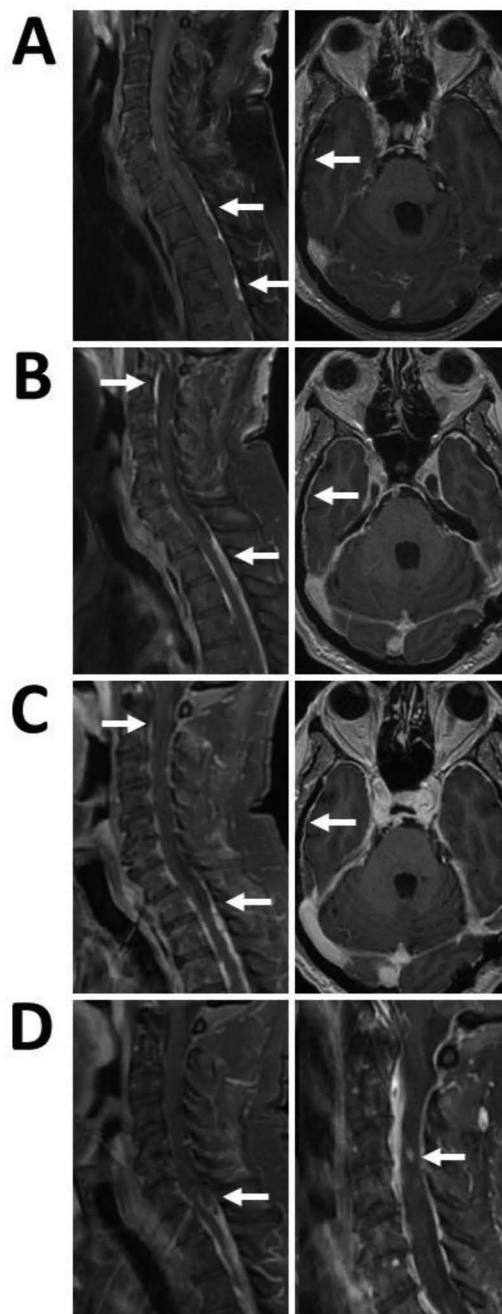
Radiologic course before and after treatment with bevacizumab. Spinal (left, A–D) and cranial (right, A–C) MRI showing leptomeningeal contrast-enhancing lesions (A, arrows) which progressed over a period of 4 months (B). Durable stable disease was observed for up to 12 months after initial treatment with bevacizumab (C). The pattern of progression included progressive cystic leptomeningeal tumor (D, left, white arrow) and an intramedullary lesion (D, right, white arrow).
